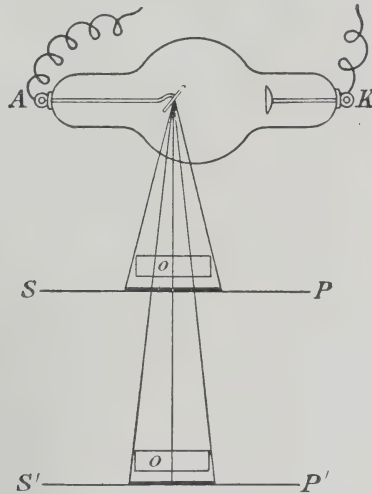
The Rays from the Target of the x-ray Tube, *AK*, diverge from one point so that the object *O*, met first by the rays, would appear larger on the photographic plate, *SP*, than it would on a similar plate (*S' P'*) situated farther away from the tube.
